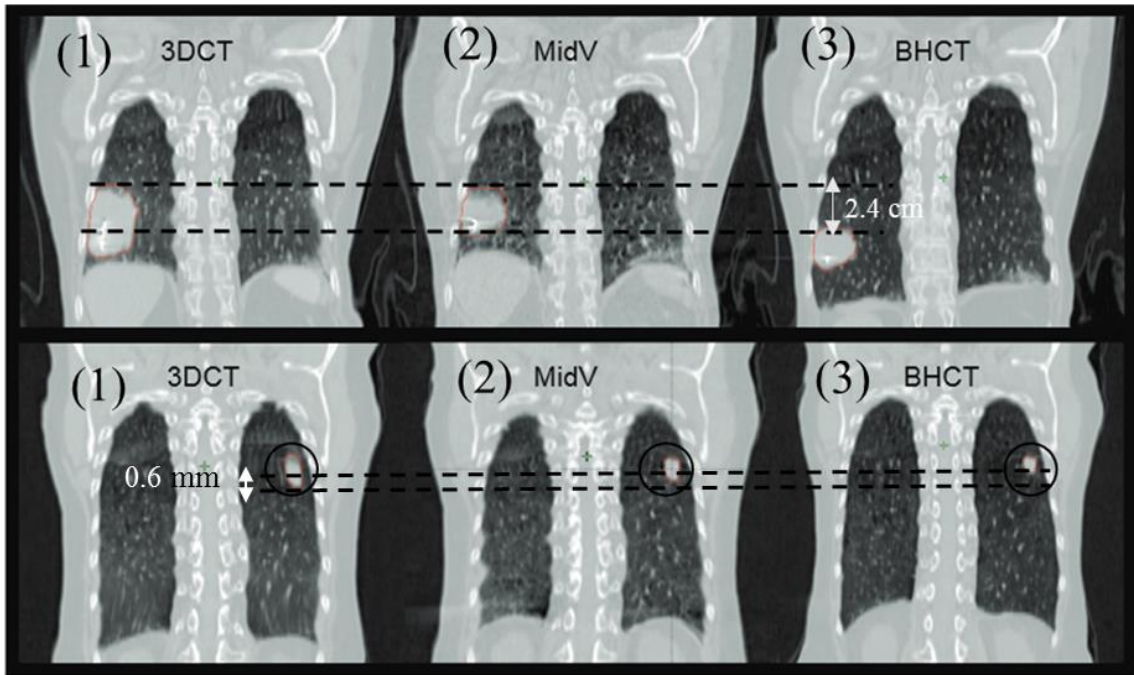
CT scans of two patients with large deviations in gross target volume (GTV) between lung scans: (1) conventional three-dimensional CT (3DCT), (2) four-dimensional CT (4DCT) mid-ventilation bin (MidV) and (3) breath-hold CT (BHCT). The upper row shows images from a patient with a tumour in the right lower lobe, the craniocaudal (CC) tumour motion was 2.4 cm. The lower row shows a patient with a tumour in the left lower lobe. The CC tumour motion was 0.6 mm, reproduced with permission from [180].
